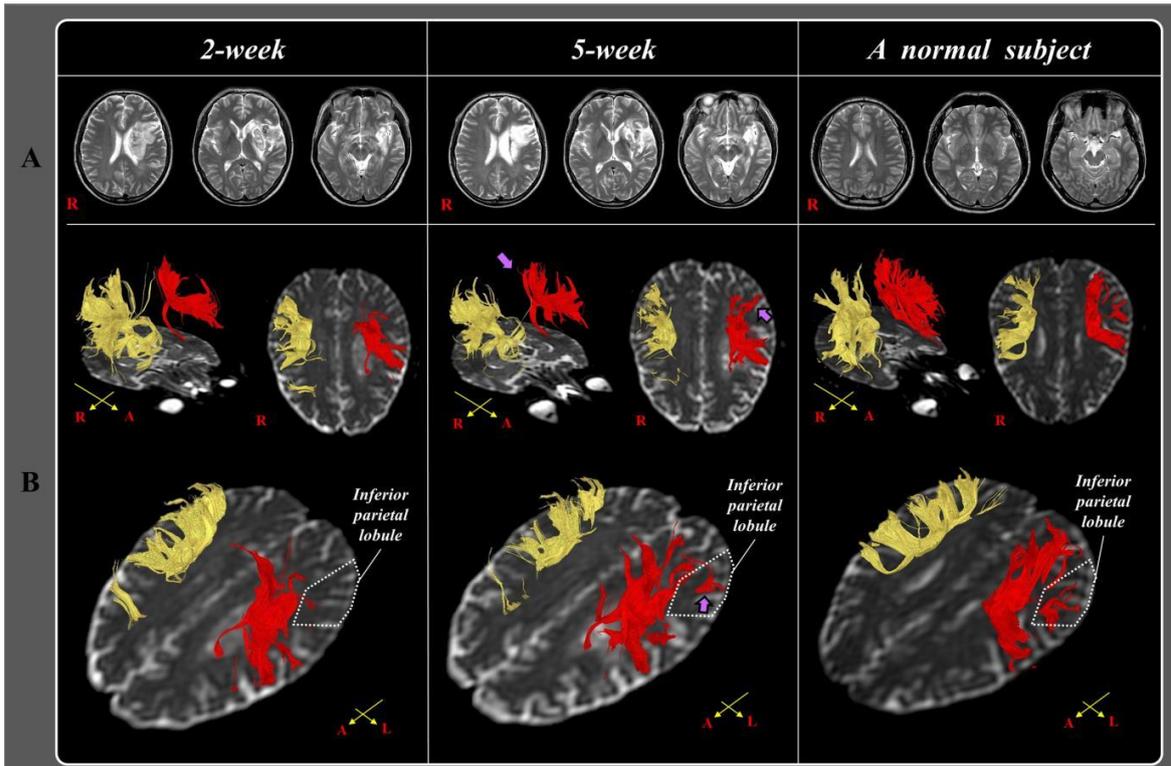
A: T2-weighted brain MR images at two weeks and five weeks after onset show leukomalactic lesions in the left middle cerebral artery territory. B: Results of diffusion tensor tractography (DTT). The left superior longitudinal fasciculus (SLF) shows injury in the inferior parietal lobule (IPL) area on 2-week DTT. By contrast, the injured left SLF extends to the left IPL area on 5-week DTT (purple arrows)
